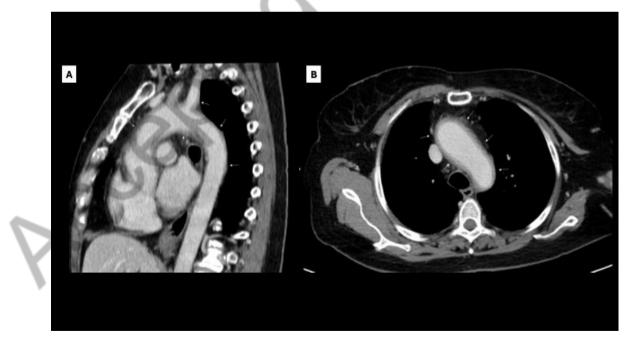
Thoracic contrast-enhanced CT images in axial (A) and sagittal (B) planes show diffuse circumferential wall thickening (arrows) of the ascendent thoracic aorta, aortic arch, proximal descending thoracic aorta and supra-aortic vessels, compatible with vasculitis.
